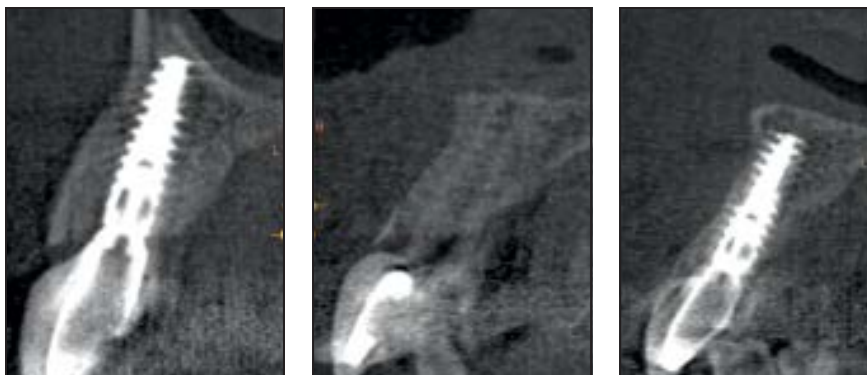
Postoperative CBCT, sliced at site 11 of the healed pontic-shield.
